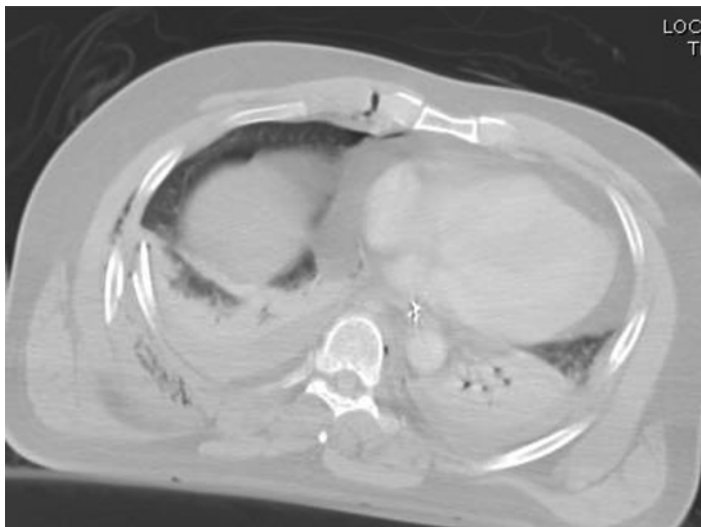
This CT scan demonstrates how the area of pulmonary contusion is typically adjacent to the area of greatest deformation of the injury to the ribs or chest
